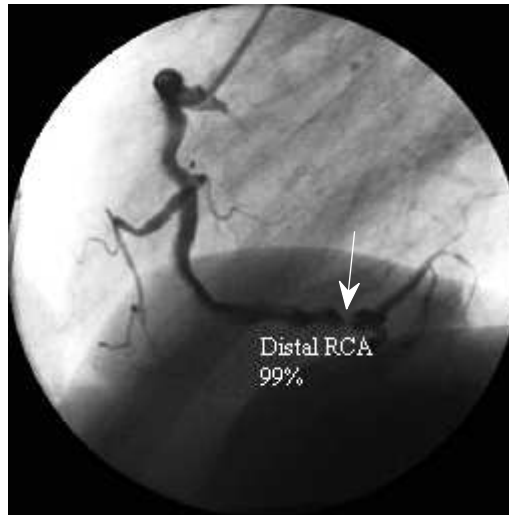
X-ray of a chest anterior view. The occlusion is marked with a white arrow
